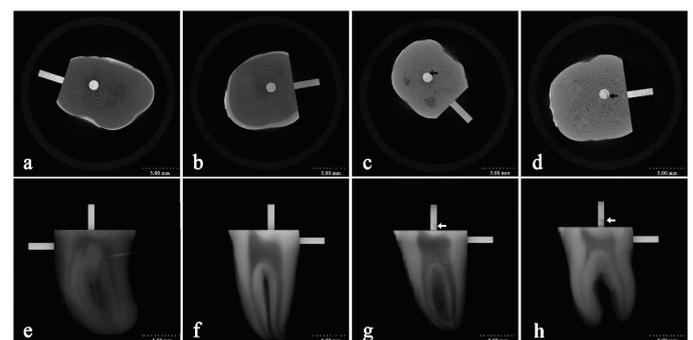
Cross-sectional radiographs and mCT images prior to the bond strength test. (Arrows represent voids within the material).
